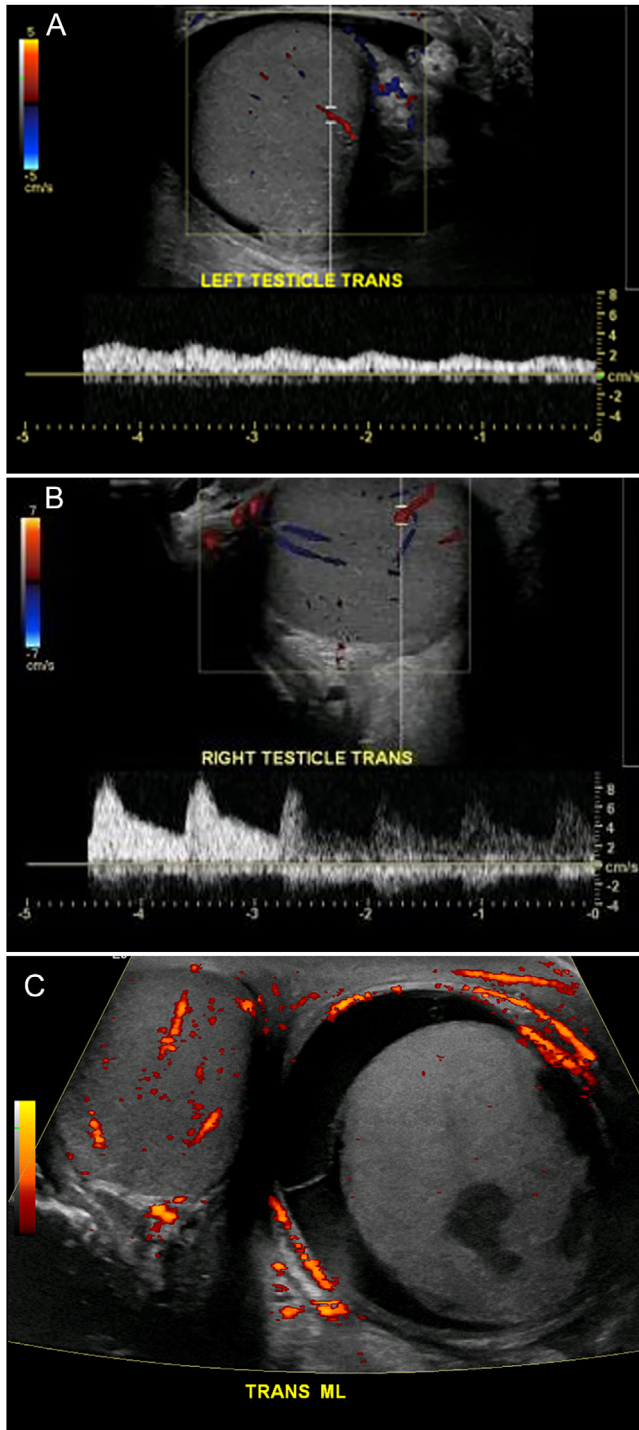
Spectral Doppler image of the right testis demonstrates an abnormal, monophasic waveform. Findings are compatible with partial testicular torsion, confirmed at surgery. Note that the presence of intratesticular flow does not exclude torsion
